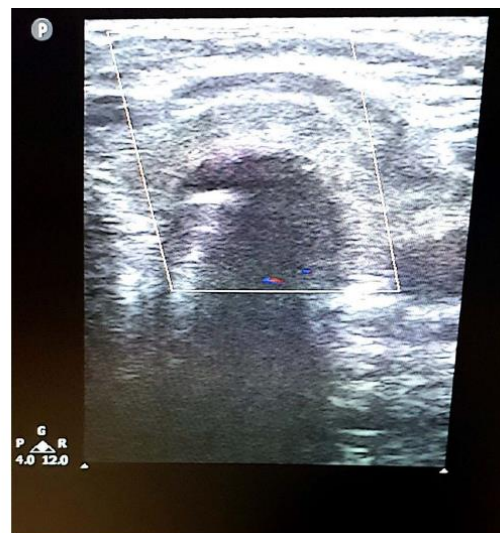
Doppler US at the level of 2nd tracheal ring for preoperative scanning of vascular structures.
